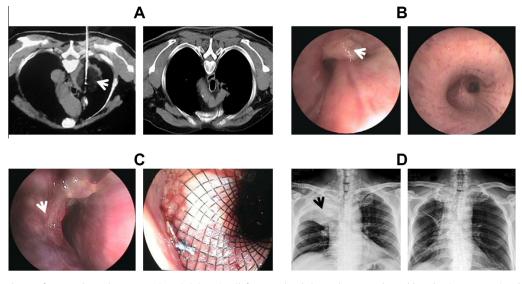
Combined cryotherapy for central type lung cancer (CTLC). (A) During (left; arrow head shows the cryoprobe and low density cryozone) and 3 months after (right) percutaneous cryoablation, an extratracheal tumor was eliminated under computed tomography guidance. (B) Before (left; arrow head shows the intratracheal tumor) and after (right) endobronchial cryosurgery, an endotracheal tumor was eliminated on bronchoscopy. (C) Before (left; arrow head shows stenosis of the tracheal wall) and after (right) airway stenting, pressure caused by an extratracheal tumor was removed on bronchoscopy. (D) Before (left; arrow head shows atelectasis caused by CTLC) and after (right) combined cryotherapy, segmental atelectasis was removed under radiographic guidance.
